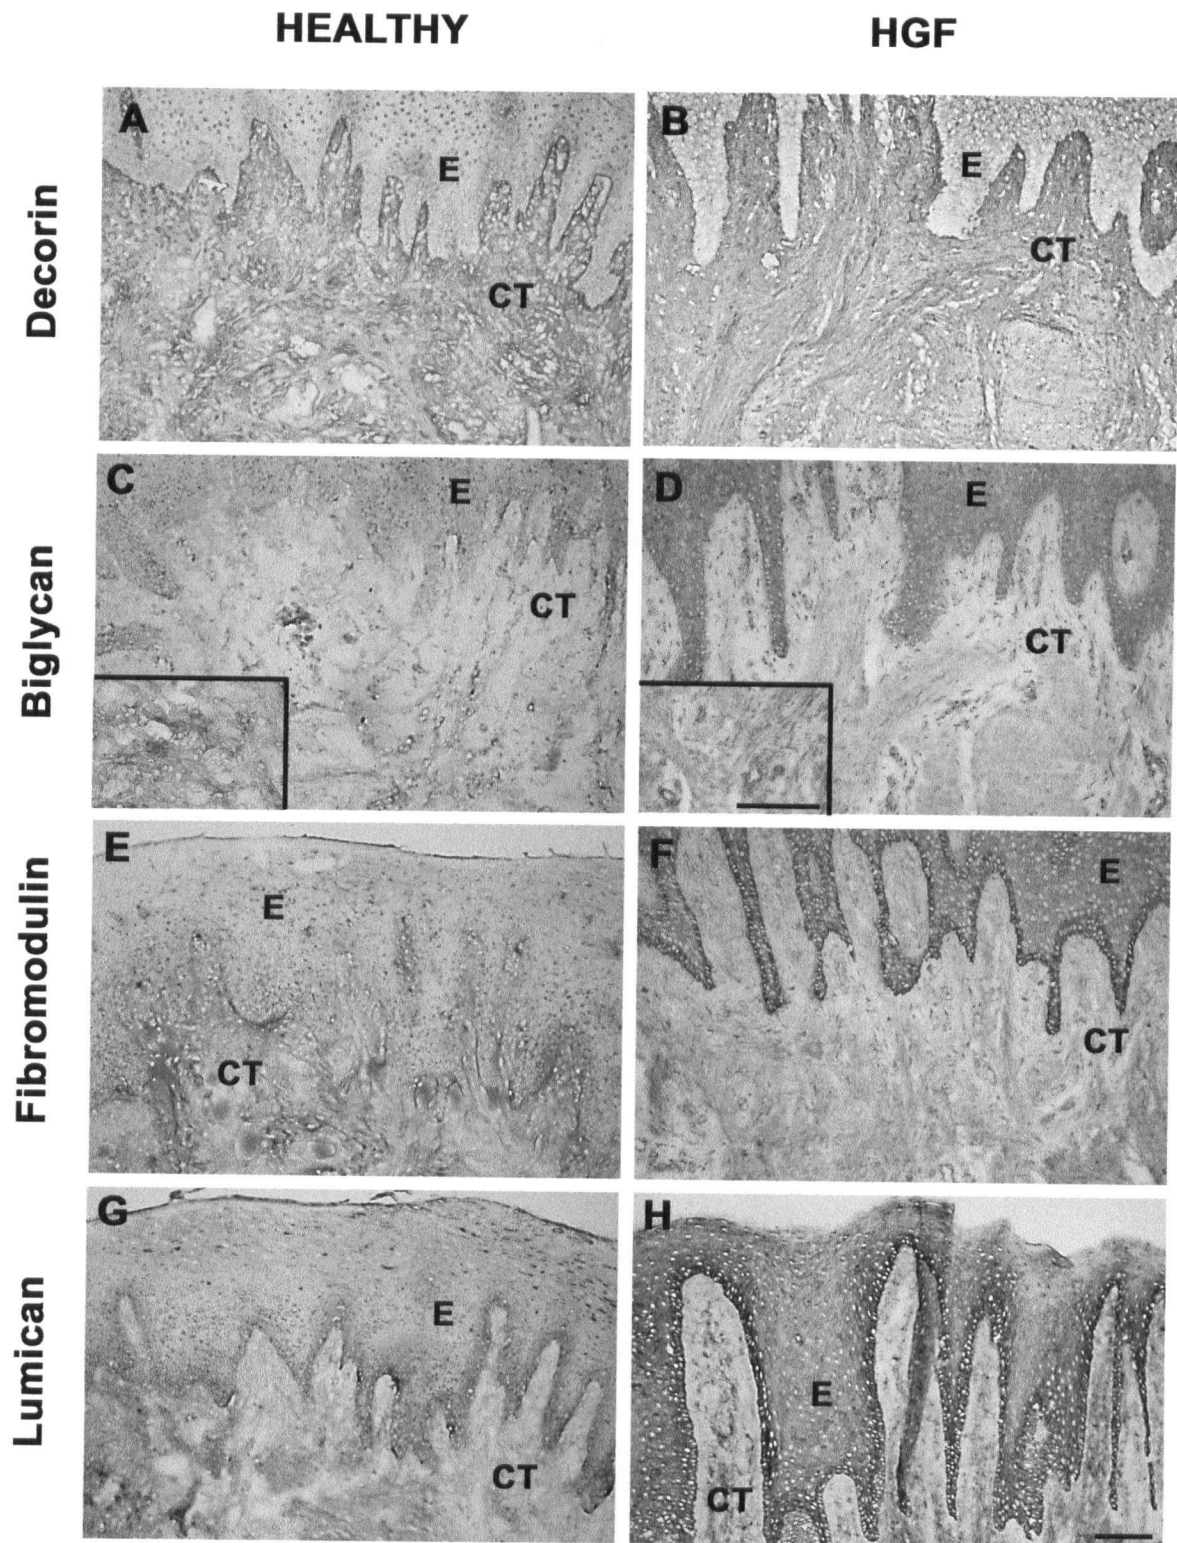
Localization of decorin (A and B), biglycan (C and D), fibromodulin (E and F) and lumican (G and H) in marginal gingiva in health (A, C, E and G) and hereditary gingival fibromatosis (B, D, F and H). E = epithelium; CT = connective tissue. Bar 100 μ m
